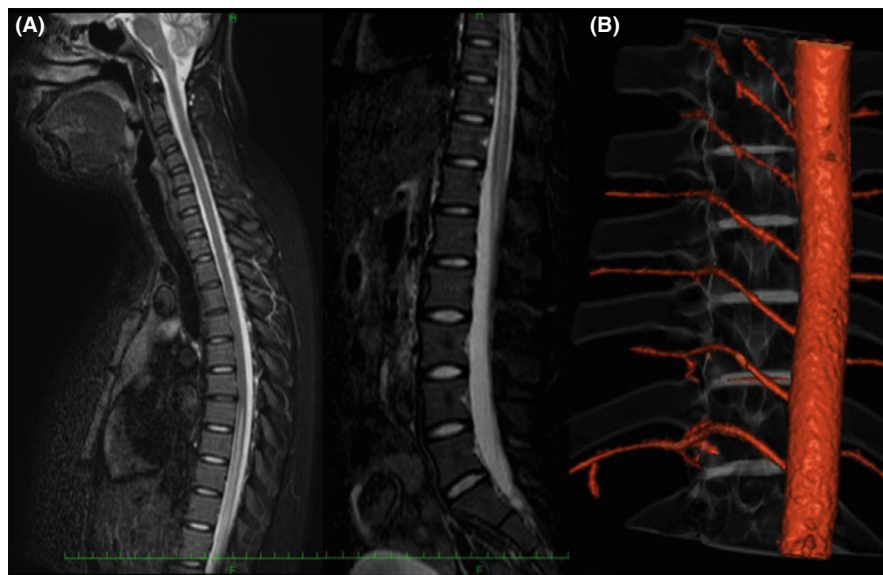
Initial imaging results of a 19-year-old woman diagnosed with surfer's myelopathy. A, Whole-spine magnetic resonance imaging on day 1. B, Computed tomography angiogram of the spinal artery on day 2.
